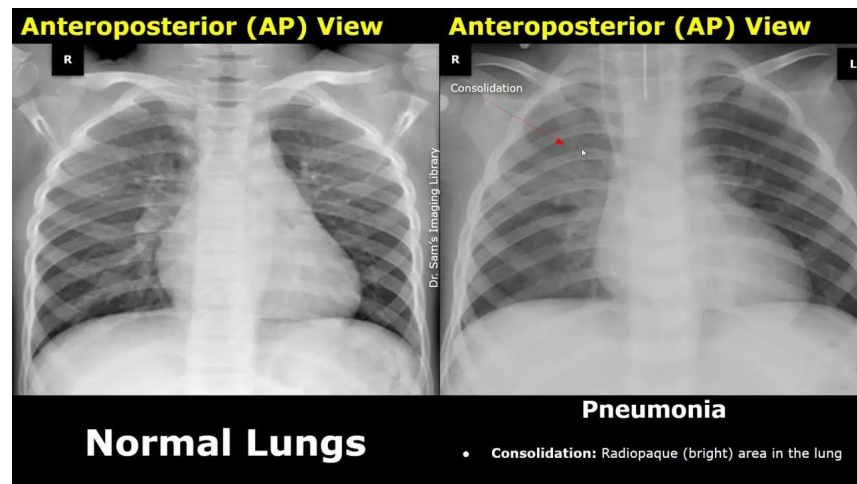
Sample Chest X-ray Images
